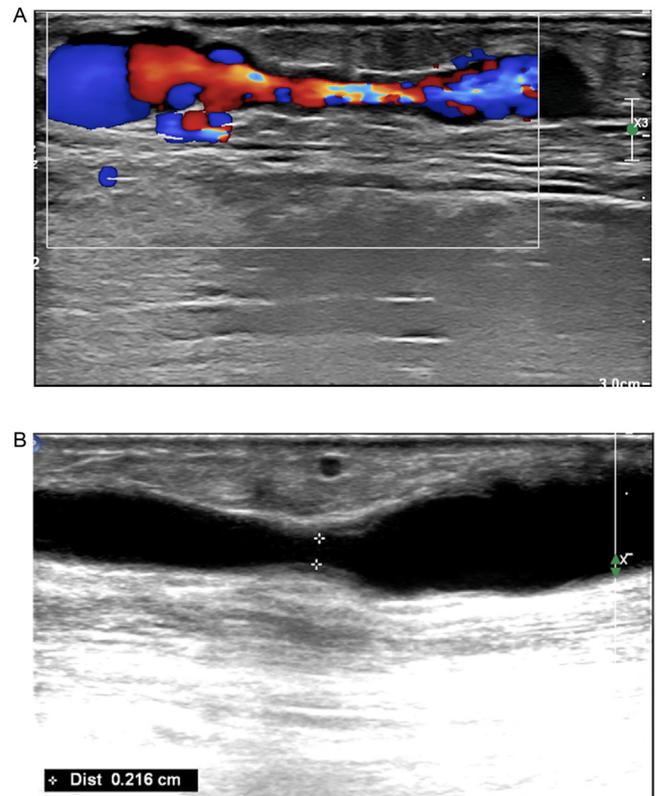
(a) Cephalic vein stenosis: color Doppler imaging. (b) Cephalic vein stenosis: B-mode imaging.
